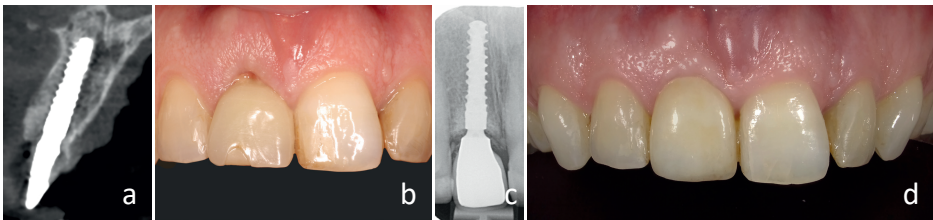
A control CBCT at the day of implant placement. b Temporary crown 2weeks after placement. c, d: radiographic and clinical image 12 months after definitive crown placement
